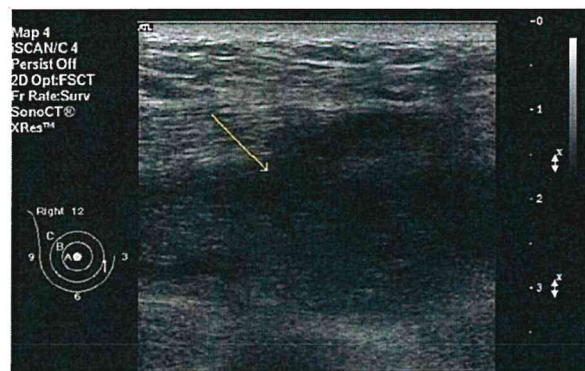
An ultrasound image demonstrates a complex fluid collection, representing the injected macrolane, with extension of this fluid into the pectoral muscle.
